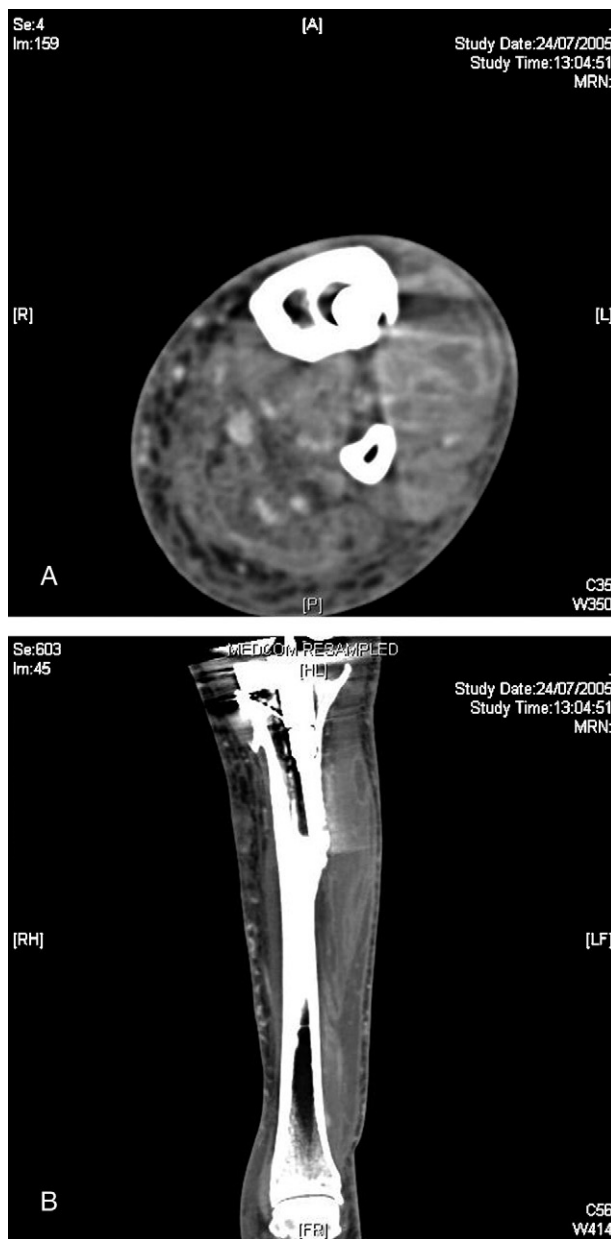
Computed tomographic scan of the calf showing communication of the intramuscular abscess with the intramedullary canal of the tibia through an undisplaced periprosthetic fracture. (A) Coronal view. (B) Sagittal view.
